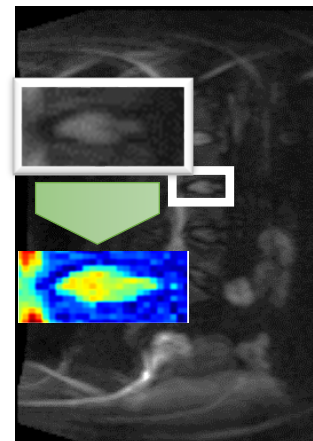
DWI scans used to create ADC maps for discs. White areas show enhanced diffusion of water.
